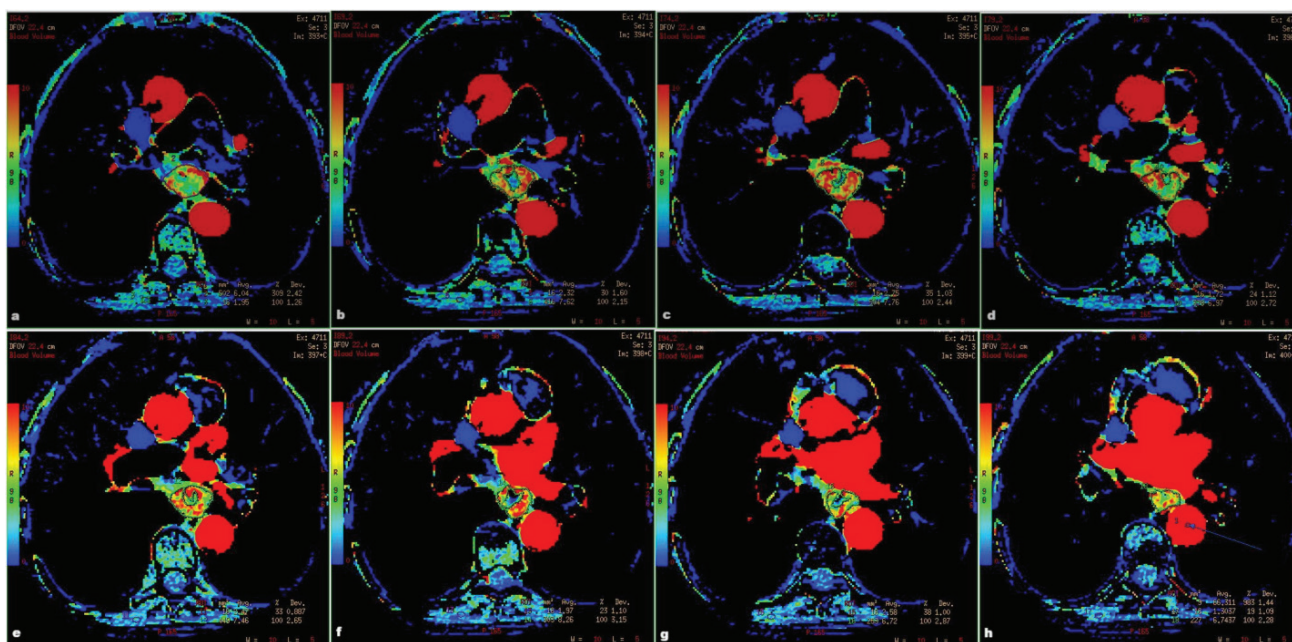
Perfusion heterogeneity in the same tumor (esophageal SCC) presented by the CT perfusion study: (a-h) BV of esophageal carcinoma and neighboring skeletal muscle on eight consecutive 5 mm-thick cross-sectional images (Images are the author's work, and written informed consent for publishing their anonymous images was obtained from the patient)
